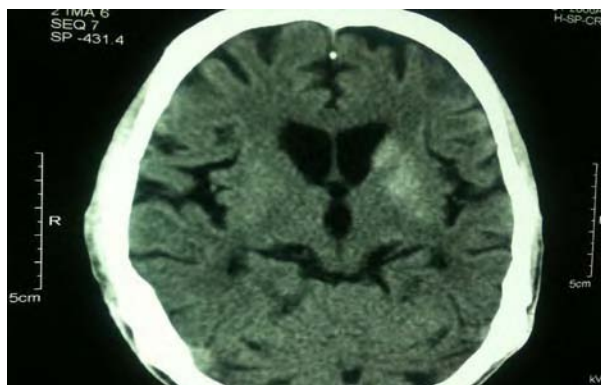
Non-contrast CT scan of brain showing hyperdensity of left lentiform and caudate nucleus.
